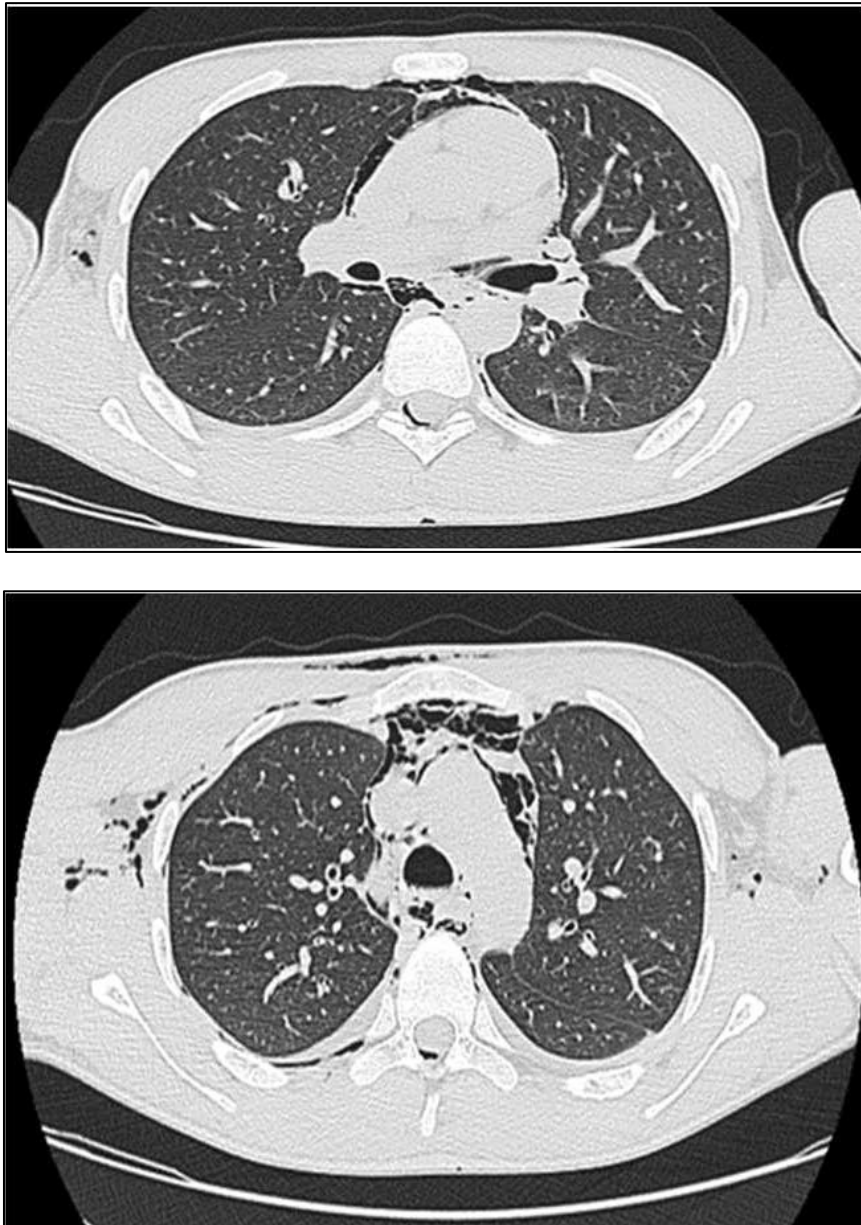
Axial chest CT images demonstrate extensive pneumomediastinum with subcutaneous emphysema, pneumorachis and, pneumopericardium
